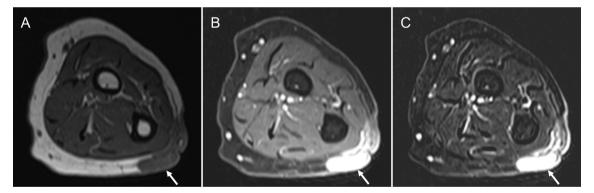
Residual soft tissue sarcoma in a 98-year-old woman who underwent unplanned excision of a myofibrosarcoma at an outside institution. Axial T1-weighted image (A), post Dotarem T1-weighted image with fat suppression (B), and subtraction post-Dotarem T1-weighted image (C) show a subcutaneous enhancing mass at the ulnar side of the left forearm (arrows). Findings are compatible with residual soft tissue sarcoma, which was confirmed pathologically after re-excision.
